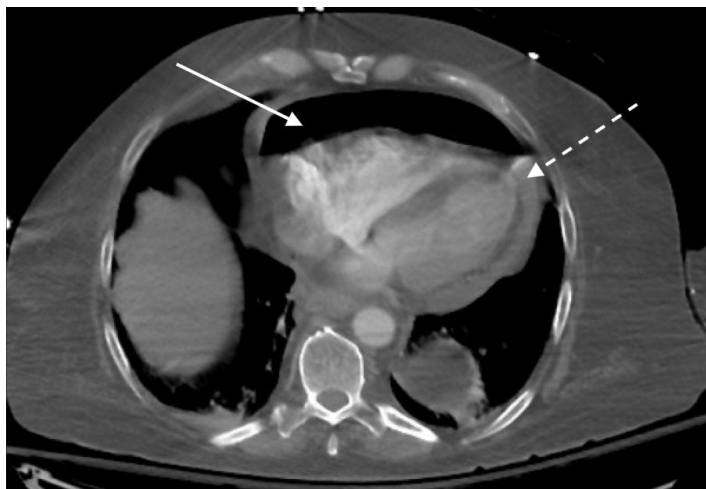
Computed tomographic angiography aortic dissection protocol, in lung window, highlighting a moderate-volume pneumopericardium (solid arrow) with associated small-volume pericardial effusion (dashed arrow).
